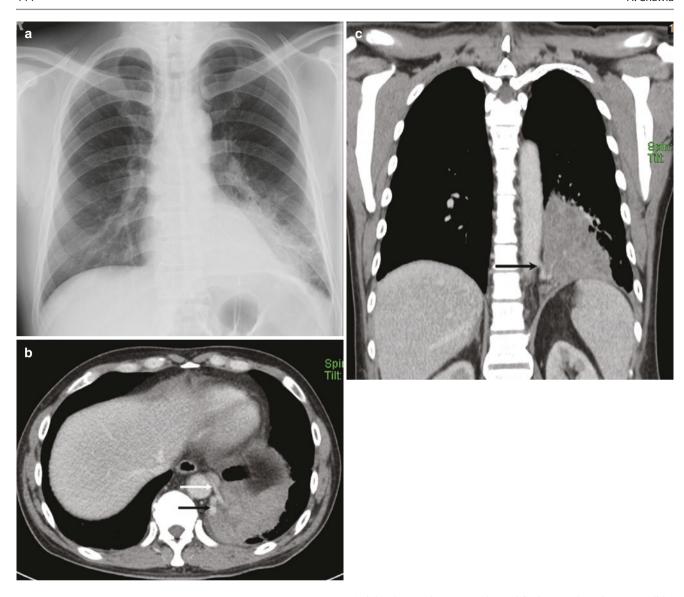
Intralobar sequestration in a 49-year-old man presenting with recurrent left lower zone pneumonia. (a) Frontal radiograph shows a left retrocardiac area of consolidation without any effusion. (b, c)
